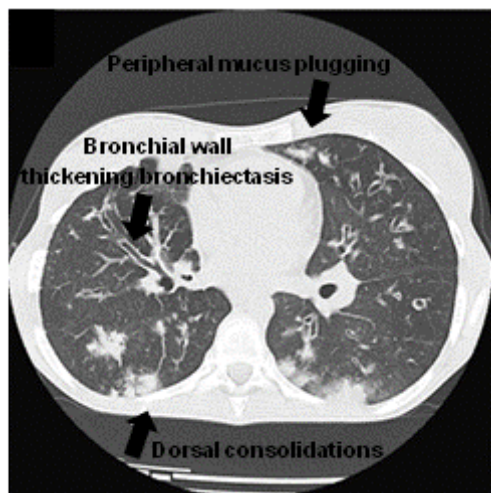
Axial computed tomographic image of the lungs of a 14-year-old girl with cystic fibrosis, demonstrating some of the morphological features of the disease (white arrows), such as bronchial wall thickening, bronchiectasis, peripheral mucus plugging and dorsal consolidations. Adapted from: [28].
